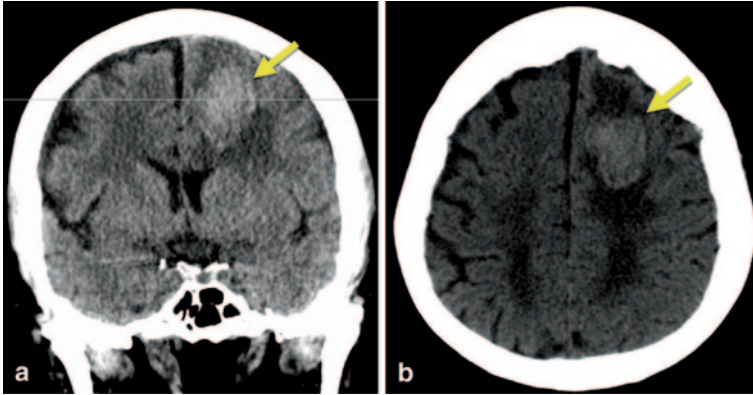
Coronal (a) and axial (b) noncontrast CT demonstrating a left frontal intraparenchymal hemorrhage (*arrow*) in a 52-year-old woman with confusion and inability to follow directions, 22 days after matched-unrelated HSCT for acute lymphoblastic leukemia with platelets 18,000/microL.
